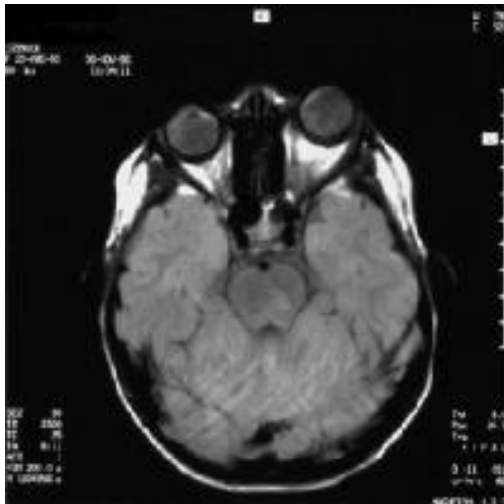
MRI showing the left optic nerve glioma with thickening of the nerve and proptosis
